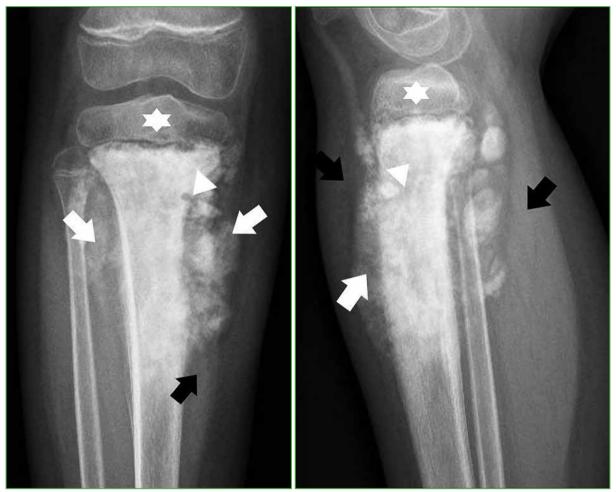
Anteroposterior (A) and lateral (B) radiographs of the right knee. A mixed lesion, with radiolucent areas (arrowhead) and radiodense areas (arrow), and a moth-eaten appearance. Poorly defined edges, a wide zone of transition without epiphyseal involvement (asterisk), and a large soft-tissue mass with increased density (black arrow) can be seen.
